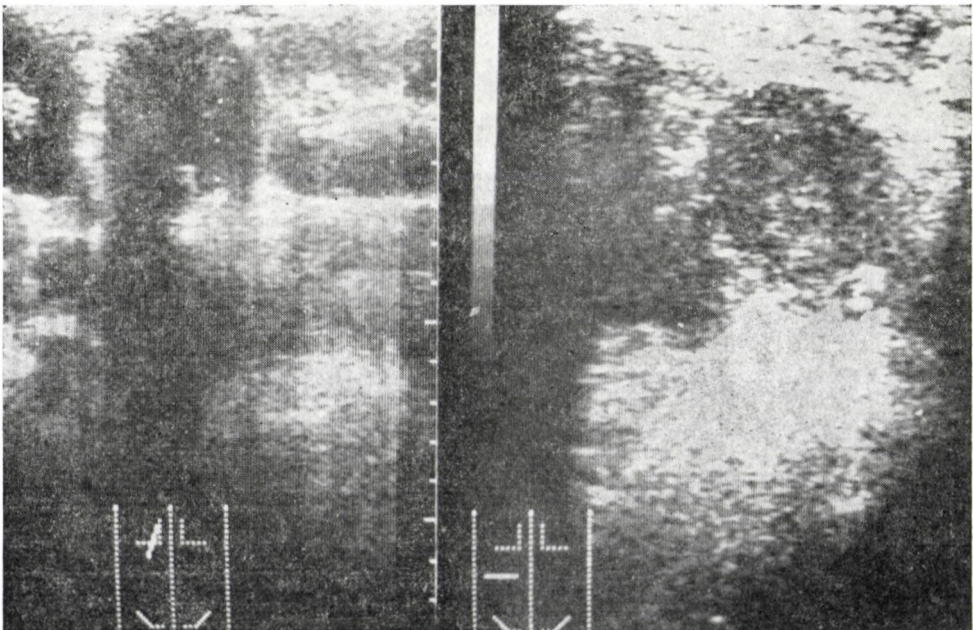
Ultrasound scan of the region of the left suprarenal gland. A round mass of about 4 cm in diameter can clearly be distinguished from the kidney and the spleen
